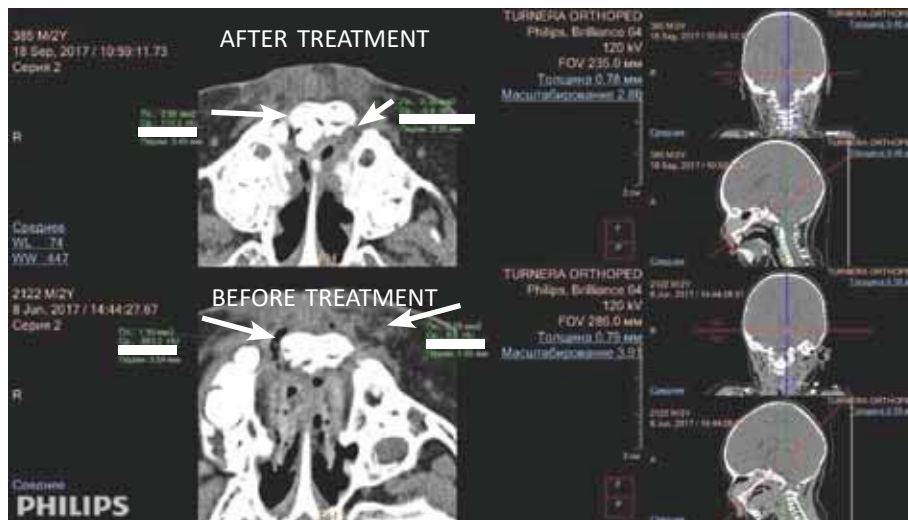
Computed tomography of patients with bilateral clefts of the alveolar process of the upper jaw before and after treatment using mesenchymal stromal cells on the right only. On the left there is a defect between the cleaved sections of the alveolar process, and on the right, where mesenchymal stromal cells were applied, the defect is filled with bone tissue
